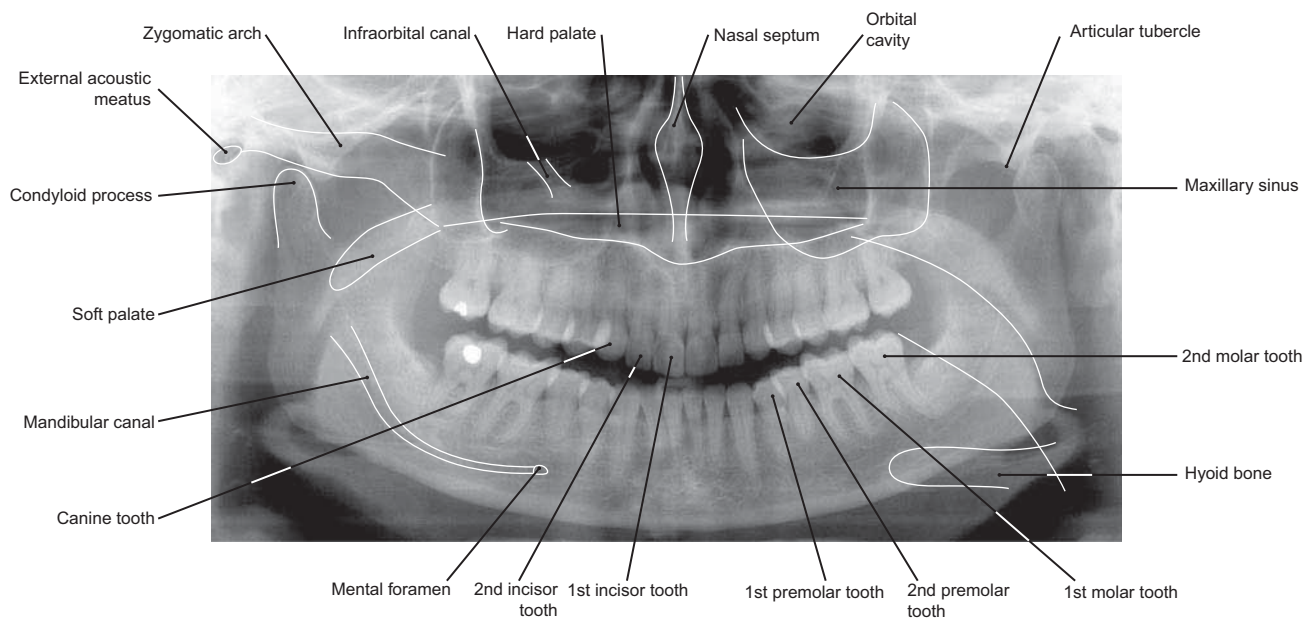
Radiograph of the Maxilla and Mandible
